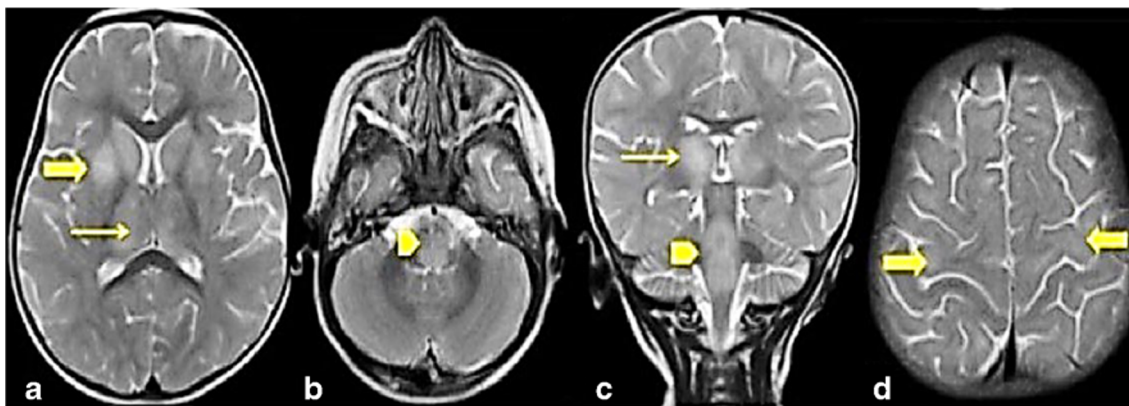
MRI brain of patient 5. Axial T2 weighted images (a, b, d) at the level of the basal ganglia, upper medullar, and high frontal area, respectively showing T2 hyperintensities in bilateral caudate heads, putamen, thalamus, pons and subcortical white matter in high frontal and parietal area. Coronal T2 weighted images (c) showing
